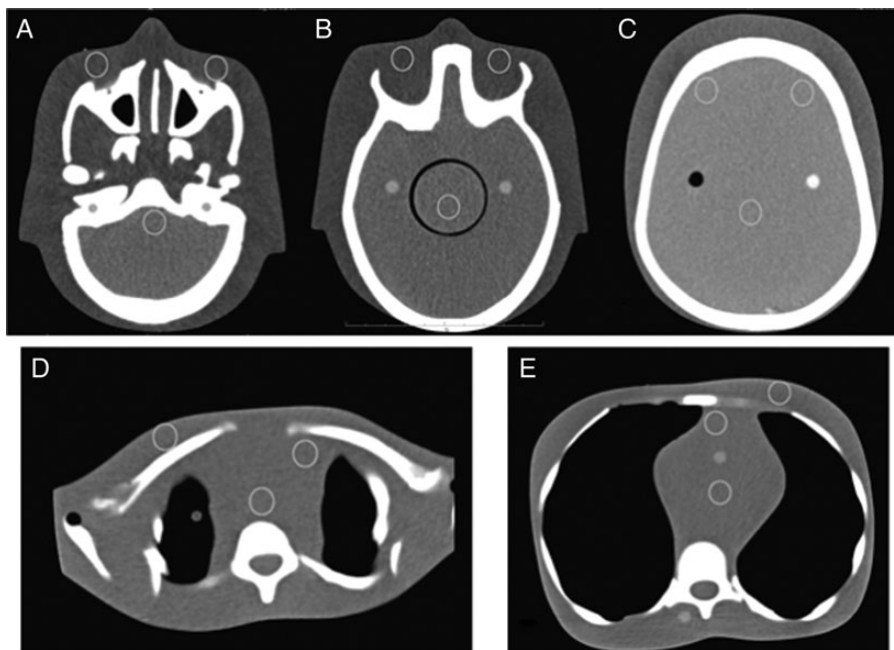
Example of ROI locations, for image analyses with OsiriX[®] software, for head (A–C) and chest (D and E) CT examinations on the AP (Model 705).
